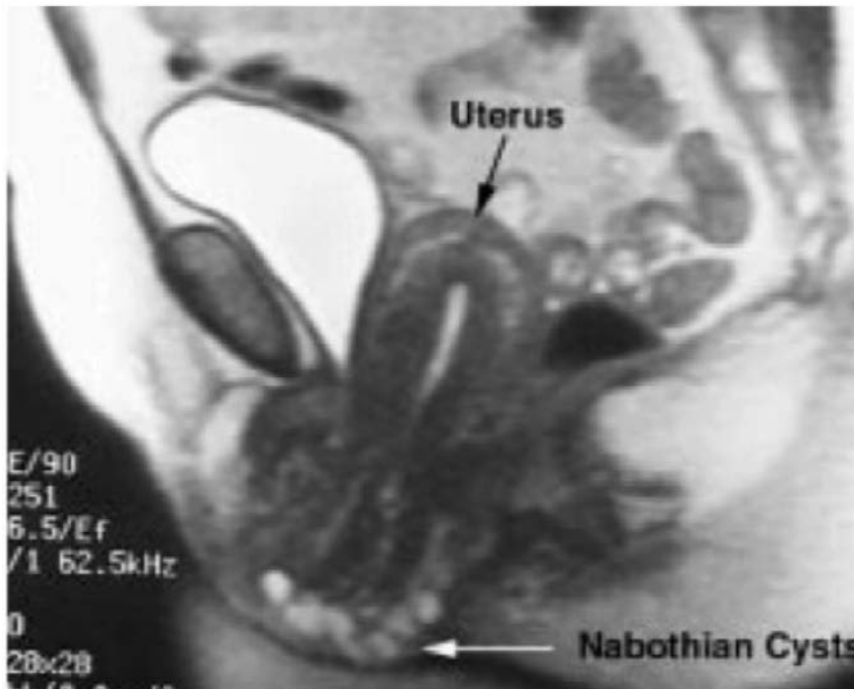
Figure B 44: Pelvic Floor MRI: Uterine Prolapse
